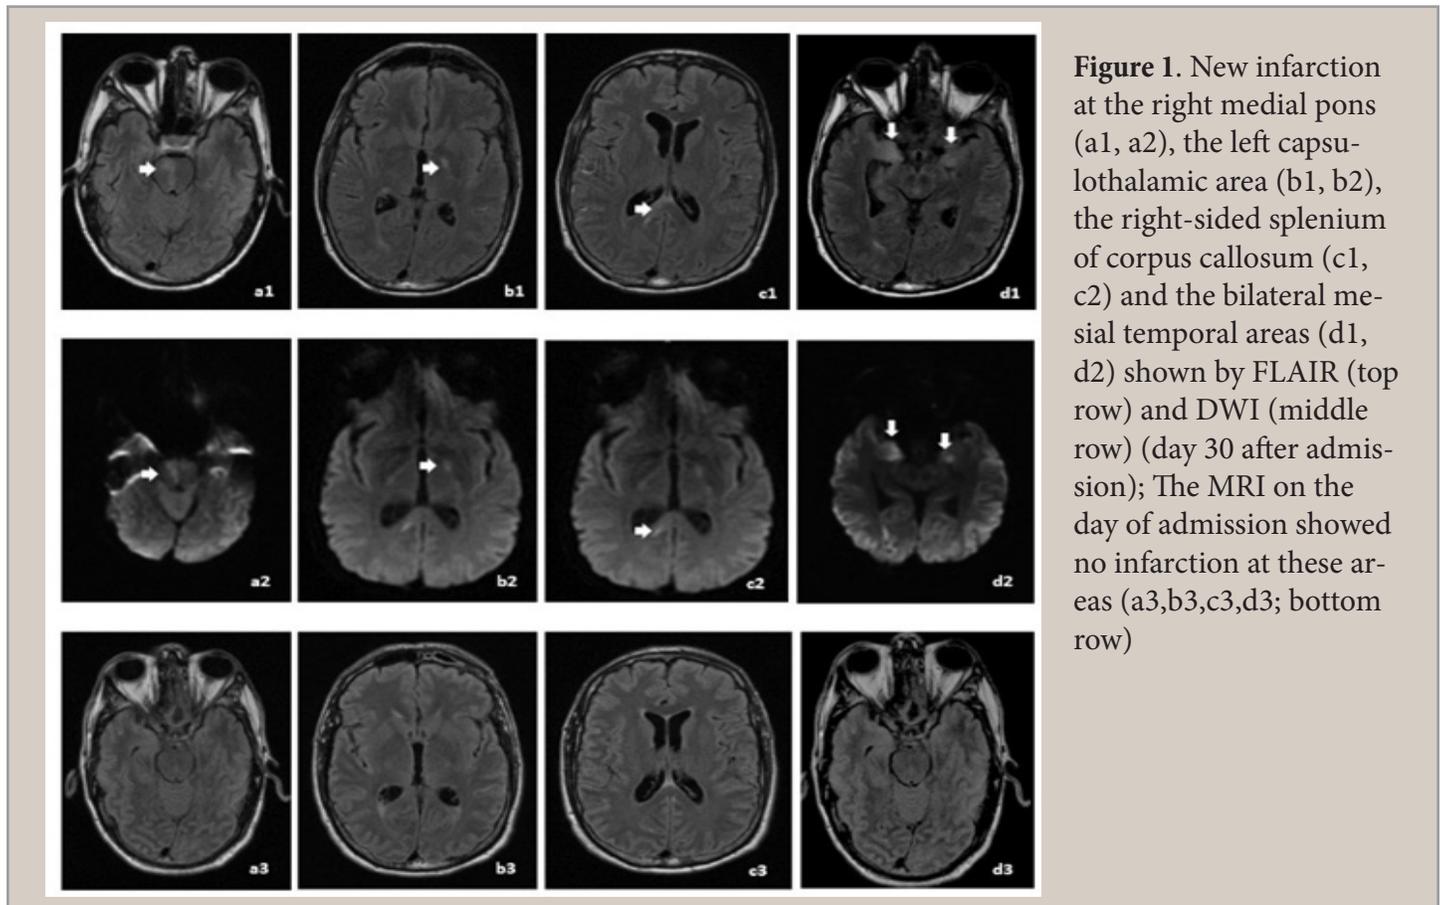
New infarction at the right medial pons (a1, a2), the left capsulothalamic area (b1, b2), the right-sided splenium of corpus callosum (c1, c2) and the bilateral medial temporal areas (d1, d2) shown by FLAIR (top row) and DWI (middle row) (day 30 after admission); The MRI on the day of admission showed no infarction at these areas (a3,b3,c3,d3; bottom row)
